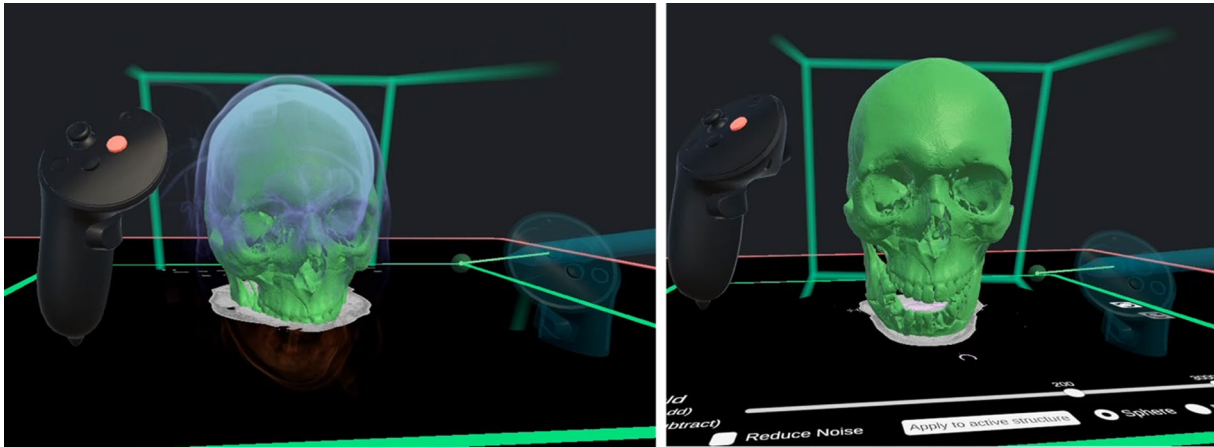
The model (green) can be manipulated freely with the tools (controllers in black and transparent turquoise), which allows an overview of the segmentation progress from all angles facilitating efficient working. The corresponding CT cross-section, is shown in the working surface.
